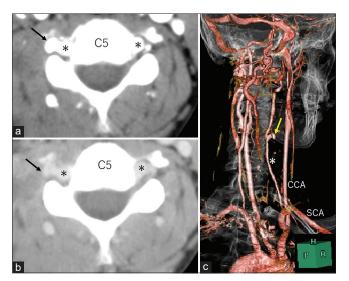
Post contrast axial computed tomography at the C5 level (a) and its delayed-phase image (b) showing lateral protrusion of the right vertebral artery wall (arrow). (c) Three-dimensional computed tomography angiography, right posterolateral view, showing an aneurysm with a maximal dimension of 10 mm projecting laterally (arrow) at the C4/C5 level. Dominance between the vertebral arteries is not observed. CCA: common carotid artery, H: head side, P: posterior, R: right, SCA: subclavian artery, Asterisk: vertebral artery.
